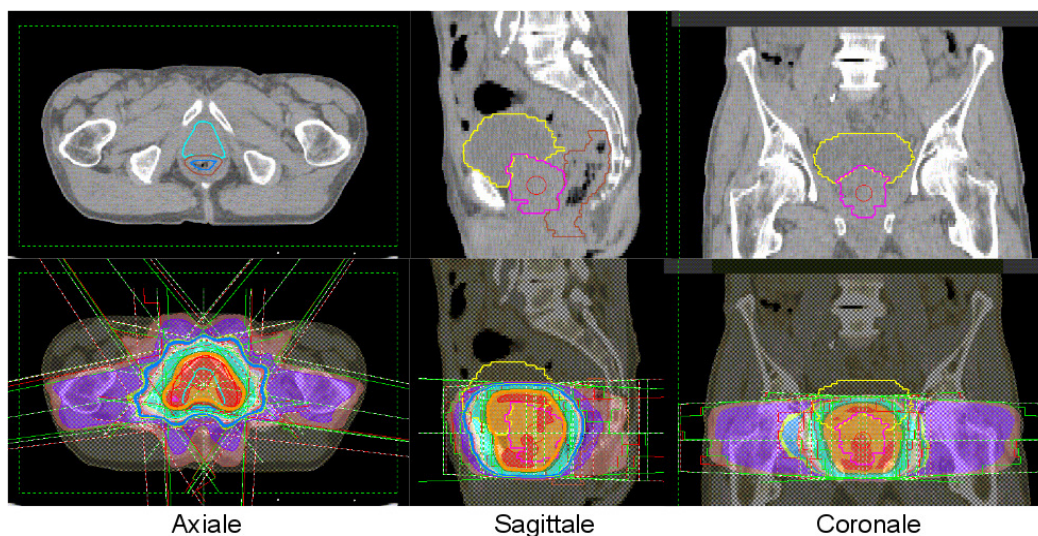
Above: Planning CT scan and the main structures delineated (prostate, bladder and rectum). Below: IMRT planning dose distribution.
